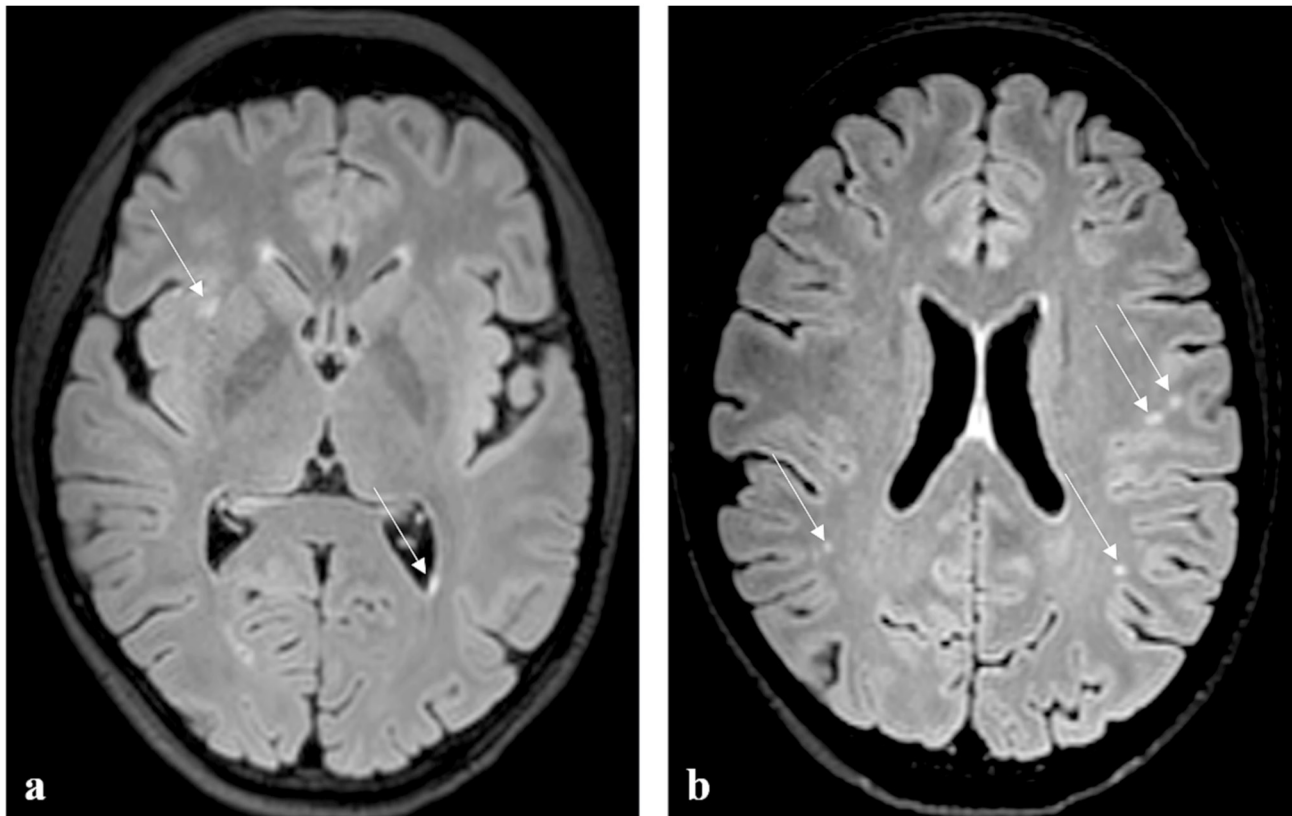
Magnetic resonance imaging, 3D FLAIR, axial reconstruction (TR/TE 4,800/269 ms). Small foci of non-specific gliosis in the white matter of both cerebral hemispheres. (a) Hyperintense FLAIR foci in paraventricular region on the left and in the insular region on the right (arrows). (b) Multiple punctate foci of gliosis in the subcortical white matter (arrows). FLAIR, fluid-attenuated inversion recovery.
